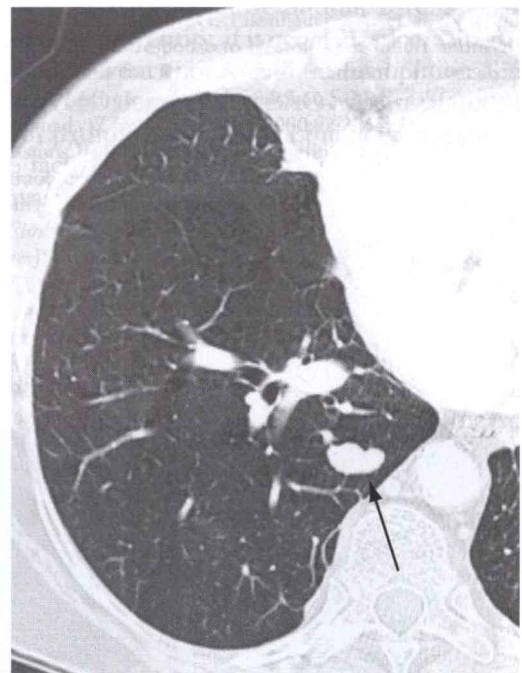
Adenocarcinoma with lobulation in a 79-year-old woman. Contrast-enhanced chest CT scan shows a lobulated 1.9 × 1-cm nodule (arrow).
